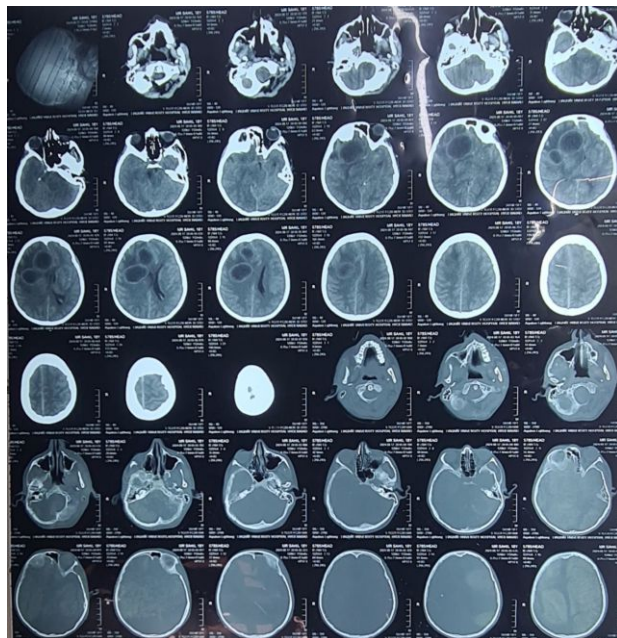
MRI Brain showing brain abscesses
